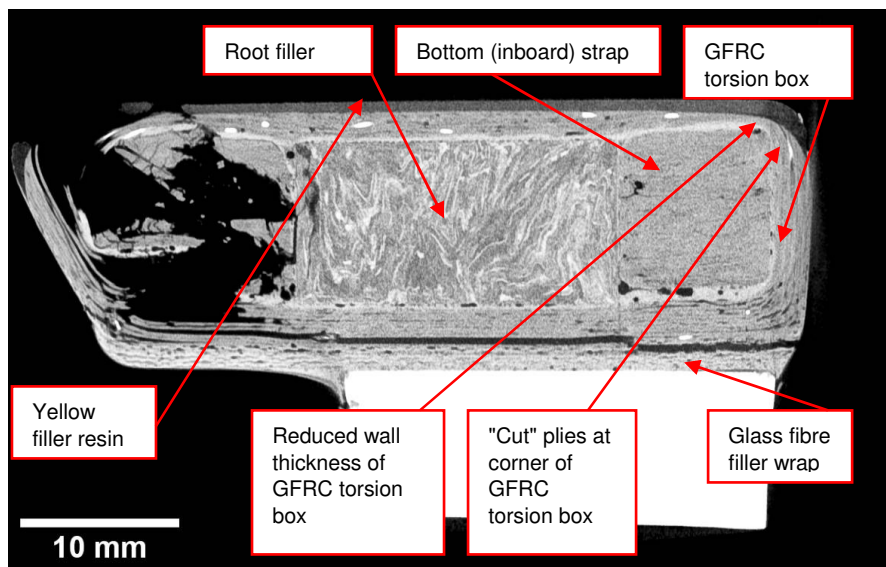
X-ray tomography image showing a plan-view slice through the fractured trailing edge arm of the White blade; slice taken just below fracture zone approximately 8 mm below the top of the pitch control arm horn
